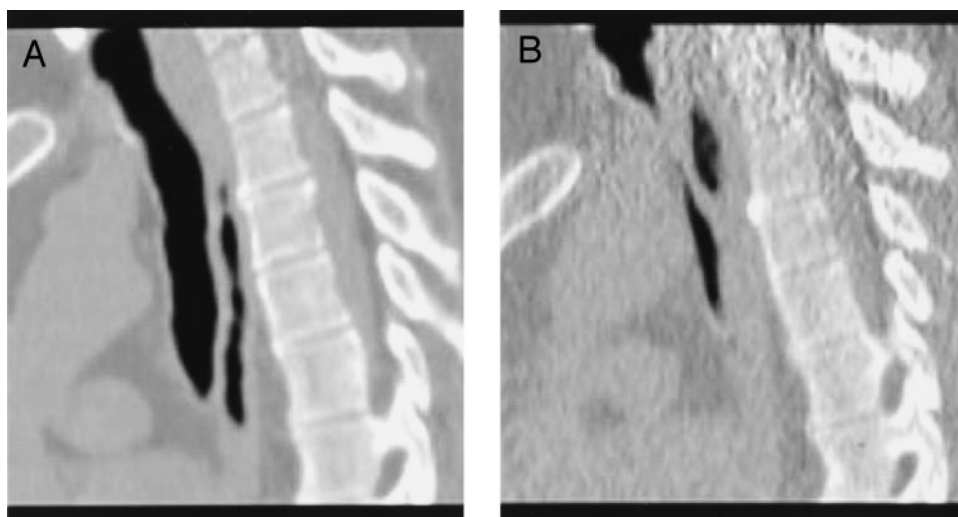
Two-dimensional CT scan airway reconstruction of the trachea. *Left, A:* the trachea during inhalation. *Right, B:* segmental tracheal collapse (arrow) during exhalation.
